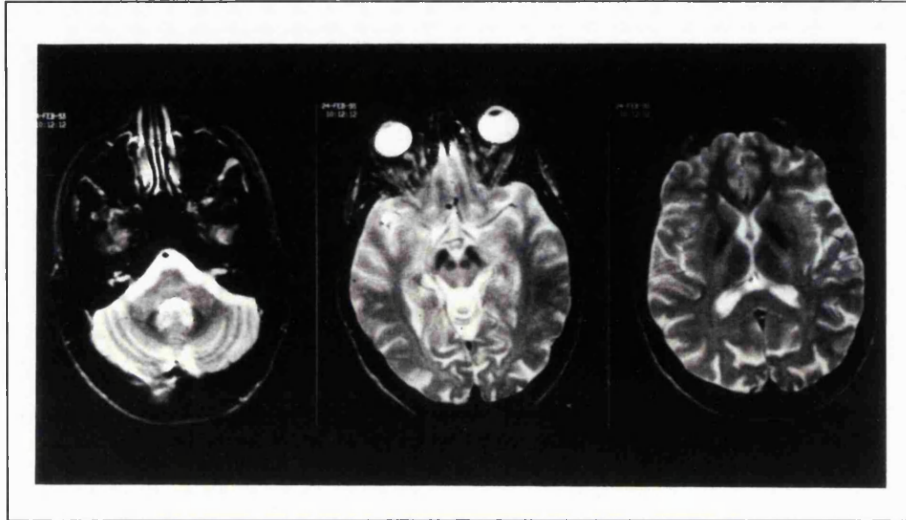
a: MRI transverse slices through the cerebellum (left), pons (middle), and basal ganglia (right). Normal study. (clinical diagnosis =Wilson's disease)
